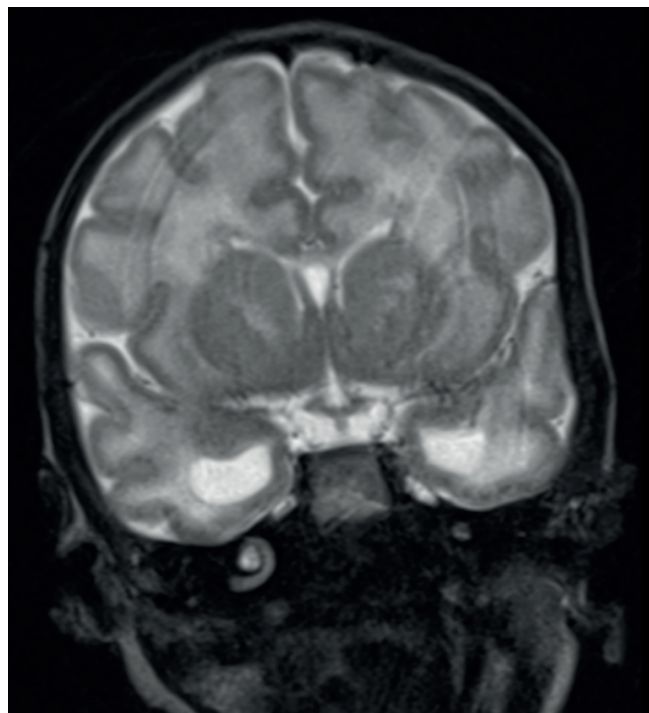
Bilateral dilation of the temporal horns of the lateral ventricles on the brain MRI
